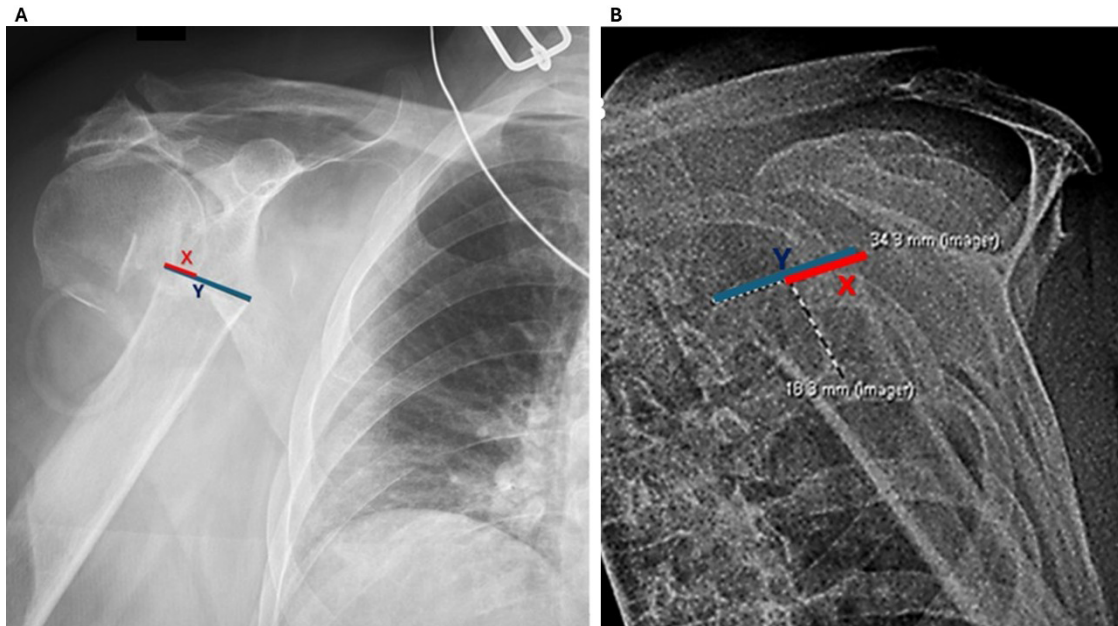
Humeral shaft coverage in anteroposterior (AP) and scapular Y shoulder radiographs. (A) The rHSC_{AP} (AP view) is calculated by dividing the metaphyseal width covered by the humeral head (X, red line) by the total width of the humeral metaphysis (Y, blue line). (B) The rHSC_Y is calculated similarly (X/Y). The total HSC will be HSC_{AP} X HSC_Y. In this example, rHSC_Y = 18.3/34.3 = 53.35%. Images are original, de-identified radiographs provided by the authors.
